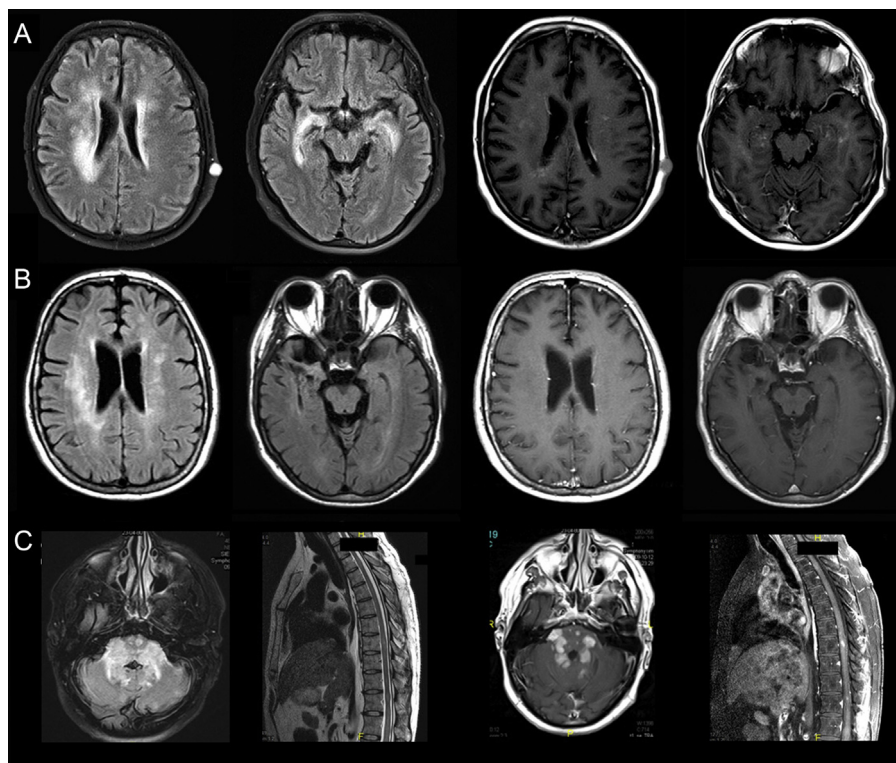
Axial FLAIR imaging (TR/TE/TI; 8500/100/2000 ms) and postcontrast T1-W imaging series obtained at presentation (A) and 6th months after treatment (B) in patient one and at presentation in patient two (C). Prominent periventricular hyperintensity and micronodular contrast enhancement are seen in the basal temporal lobes and deep cerebral white matter. Progressive ependymal contrast enhancement is also observed (A). 6 months following the diagnosis and treatment, disappearance of periventricular hyperintensity along with ependymal contrast enhancement with some residual nonenhancing hyperintense lesions. Please note the postsurgical defect of the right temporal lobe and absence of the left parietal subcutaneous nodule due to its excision for pathologic examination (B). Axial lesions mainly in the middle cerebellar peduncles, brain stem and cerebellum with nodular contrast enhancement is seen. Cervical and thoracic lesions with contrast enhancement are also present in patient two (C).
